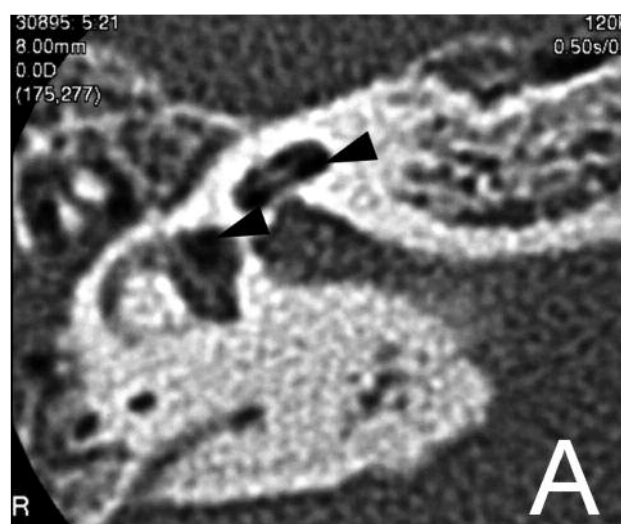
Preoperative computed tomography of the right temporal bone. Right axial view of computed tomography of the temporal bone shows air bubbles (arrowheads) trapped in the vestibule and the cochlea (A). Right coronal view of computed tomography of the temporal bone shows an air bubble (arrowhead) trapped in the vestibule (B).
